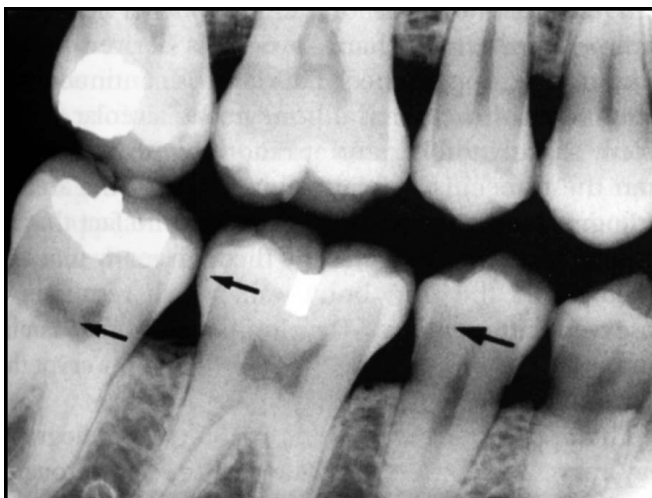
Teeth are composed of pulp (arrow on the second molar) enamel (arrow on first molar), dentin (arrow on second premolar), and cementum usually not visible radiographically
